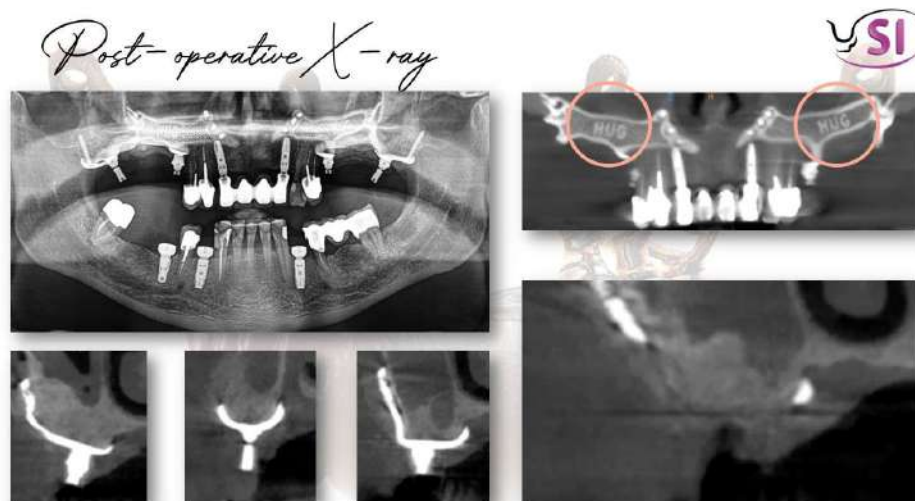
Postoperative panoramic radiograph and CBCT sections. The implant traceability codes are visible in the lattice structure on the panoramic view.
